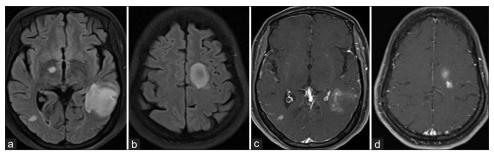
(a) FLAIR hyperintense lesion in the left posterior temporal region other similar hyperintense lesions in the right temporal and ganglionic nucleus. (b) Similar lesion in the left centrum semi-ovale. (c and d) Post-contrast study shows patchy enhancement of both lesions
